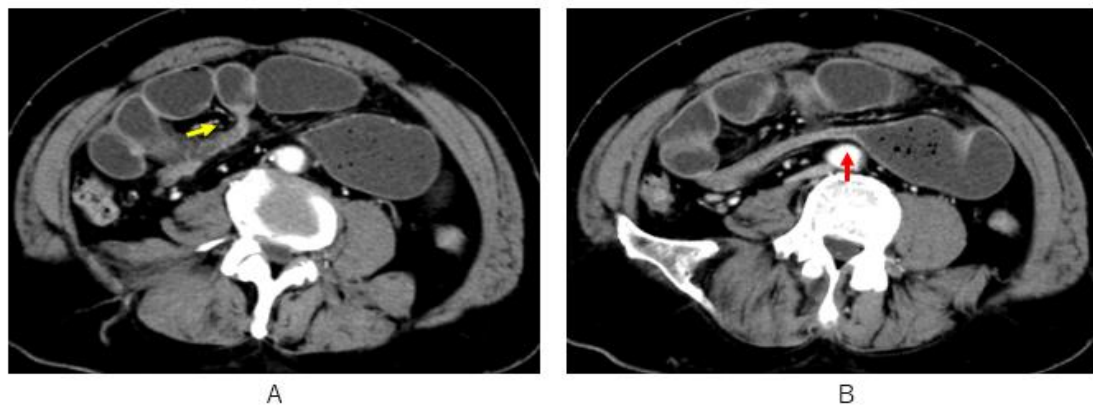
Small bowel mural including both occlusive transposition sites (A, B arrows) are well enhanced on contrast-enhanced CT.
